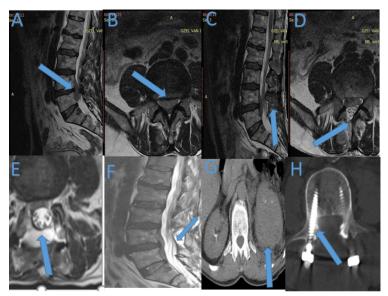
A-B, A 61-year-old male patient with primary renal cell carcinoma. First preoperative lumbar axial and sagittal T2 MR images. Epidural mass compressing the spinal canal. The patient was operated on considering the lumbar disk hernia in the external center (arrow). C-D, First postoperative axial and sagittal lumbar T2 MR images. Right L4-5 hemilaminectomy defect (arrow). E-F, Second postoperative lumbar sagittal and axial T2 MR images. Removal of tumor tissue with total laminectomy (arrow). G-H, Second postoperative vertebra CT images. Pedicle screw and a giant mass in the left kidney (arrows).
